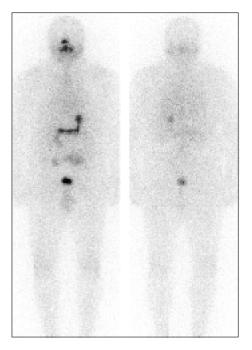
A 43 year-old man with papillary thyroid cancer. Diagnostic scintigraphy after 300 MBq of ¹³¹I. Without thyroid remnant or accumulated metastases.
